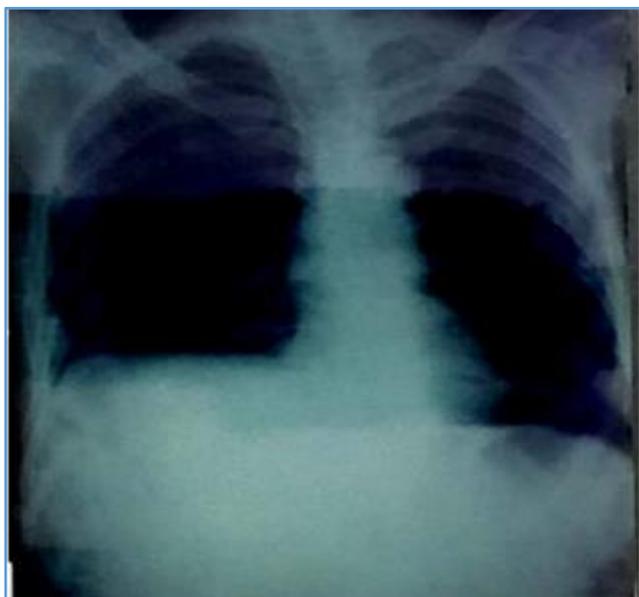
Chest X-ray Showing Elevated Right Dome of the Diaphragm with Minimal Effusion Right Side
